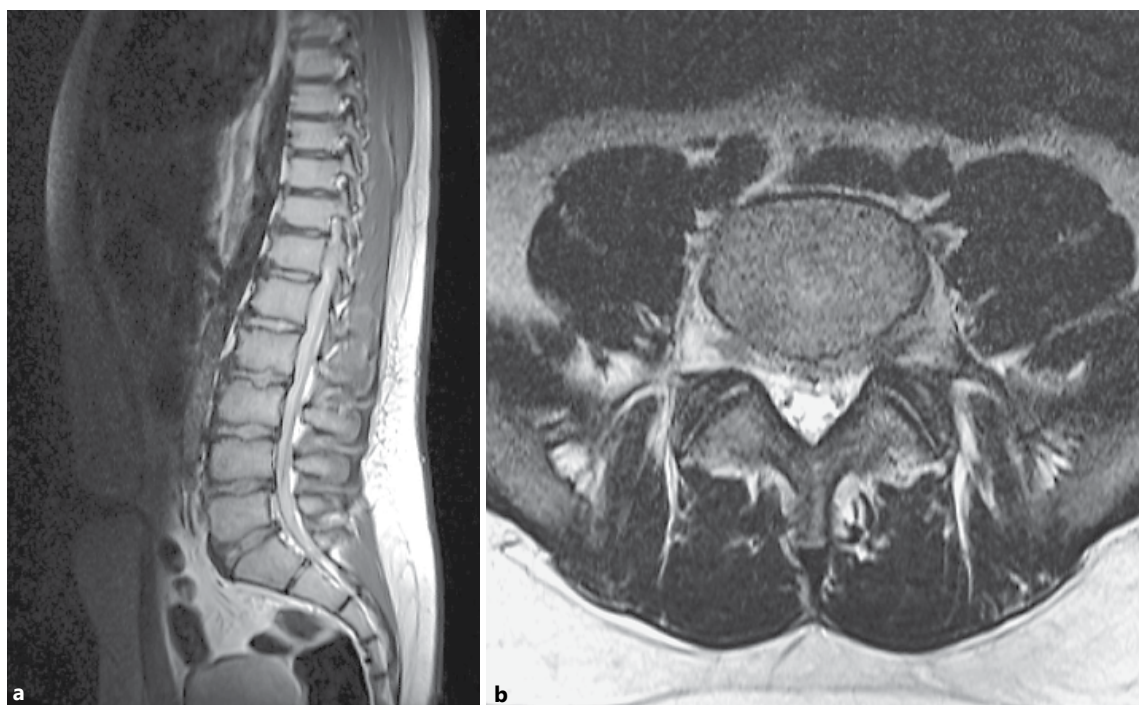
a, b Atypical polysegmental lumbar changes seen in MRI associated with lumbar spinal stenosis in an overweight 14-year-old adolescent male (BMI 30.4) admitted to the hospital with acute pain and neurological deficits.
